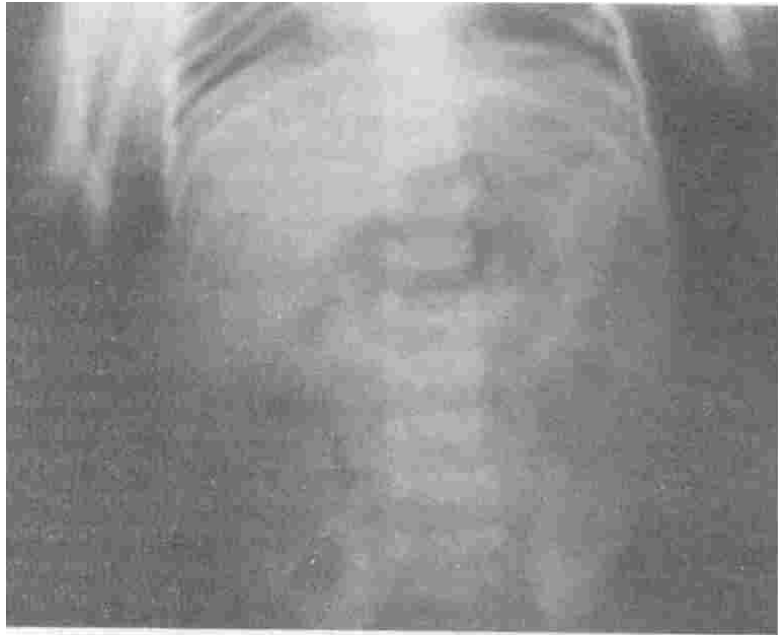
X-ray abdomen showing intramural gas and thickened bowel loops.
